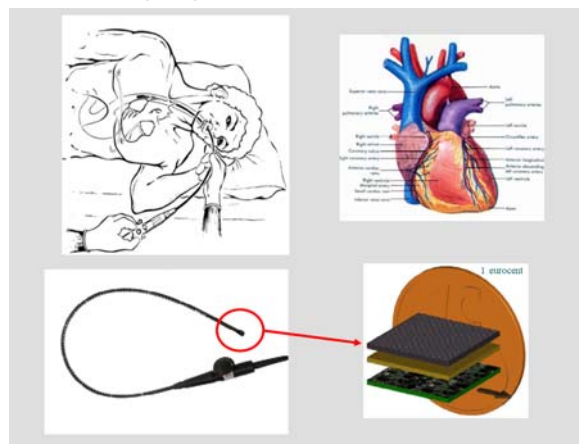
TEE probe for 3D echocardiography
